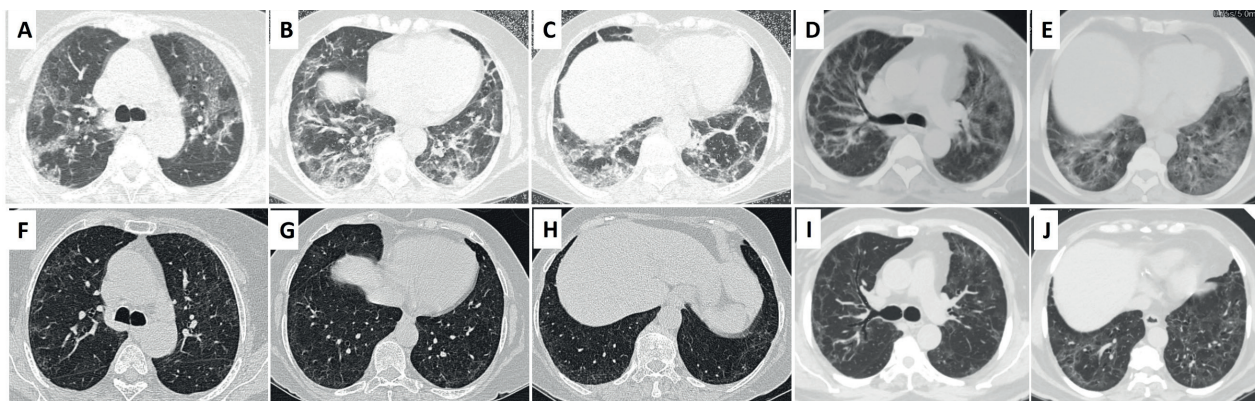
CT scan of chest of our first patient at presentation (A, B and C) (fifth week after onset of COVID-19 pneumonia), and after three months of oral clarithromycin therapy (F, G and H). A, B and C - CT scan of chest at level of carina (A), and apex (B) and distal right hemidiaphragm (C) show interlobar septal thickening with ground glass opacities in peripheral distribution (A), peribronchovascular thickening (B and C), peripheral coalescing consolidation right lower lobe (C) and perilobular pattern of thickening surrounding an area of normal attenuation with a solid nodule within its center (left lower lobe) (C), suggestive of the target sign, overall favouring organizing pneumonia. CT scan of chest at similar levels (F, G and H) show subtle interstitial and ground glass abnormalities, with resolution of the earlier changes. CT scan of chest of our second patient at presentation (D and E) (sixth week after onset of COVID-19 pneumonia), and after three months of oral clarithromycin therapy (I and J). D and E - CT scan of chest at level of carina (D) and right hemidiaphragm (E) show peribronchovascular thickening and peripheral interlobar septal thickening (D), ground glass opacities seen in left upper (D) and lower (E) lobes, traction bronchiectasis in left lower lobe (E), and perilobular pattern of interstitial thickening with central clearance in right lower lobe (E) suggestive of organizing pneumonia. CT scan of chest at similar levels (I and J) shows interstitial abnormalities with reduction in ground glass opacities (I), and a thinned out remnant of the target sign seen in right lower lobe (J), with resolution of the peribronchovascular thickening and reduction in traction bronchiectasis.
